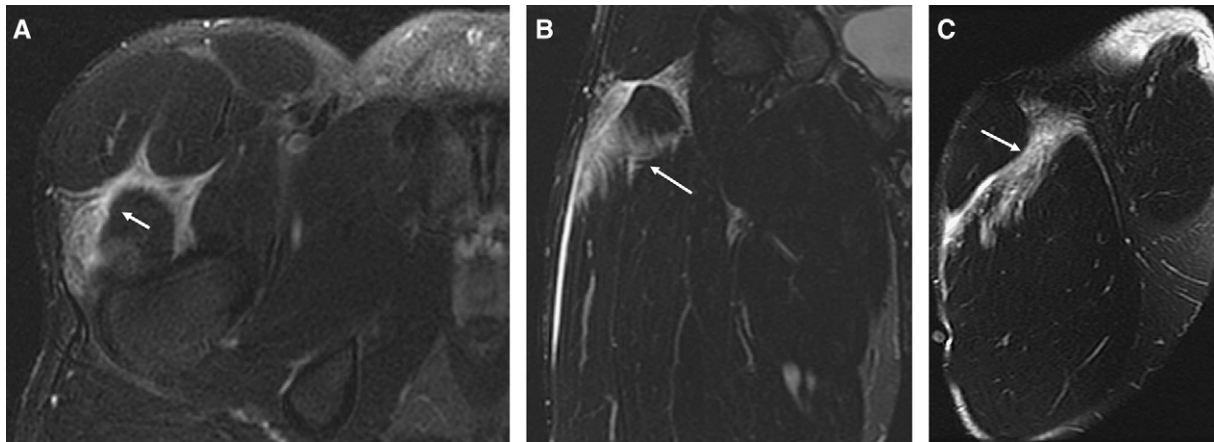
Musculotendinous junction injury of vastus lateralis. (A, B, C) Axial, coronal and sagittal fat-saturation fast spin-echo T2-weighted magnetic resonance imaging, demonstrating a grade 2 partial injury at the proximal musculotendinous junction of the vastus lateralis (white arrows). There is a crescentic fluid collection just deep to the tensor fascia lata and superficial fascia of the thigh. The patient received nonsurgical treatment and returned to professional hockey.
